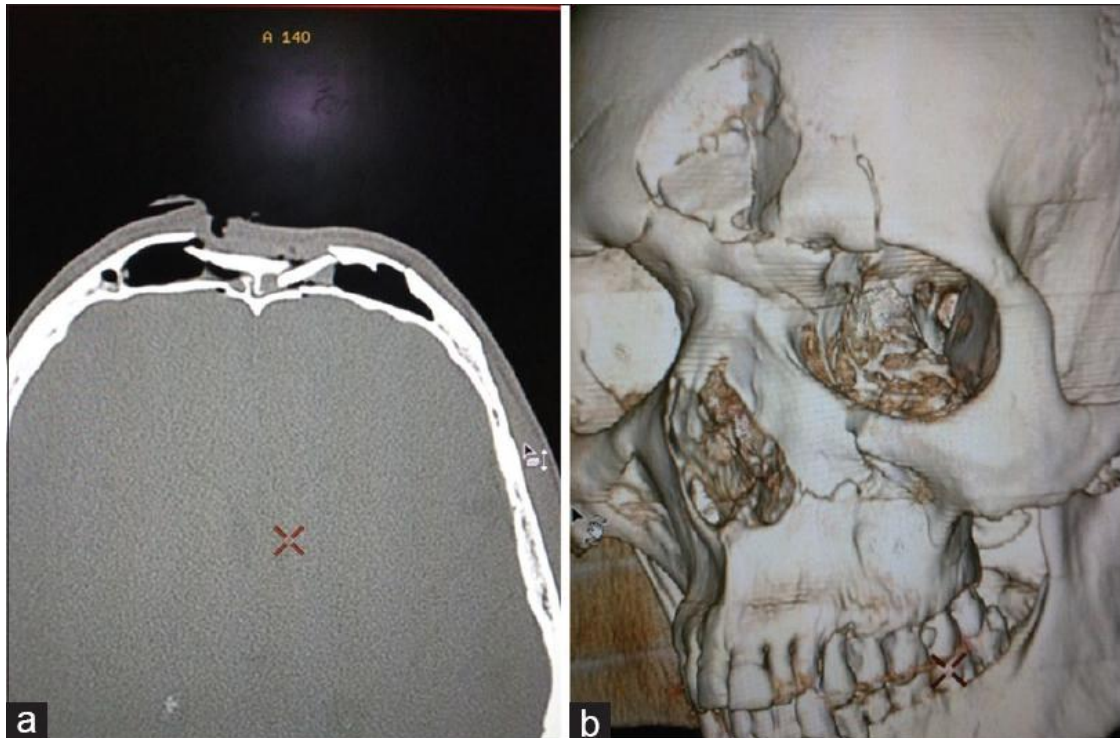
(a) Comminuted depressed fracture of the frontal bones on axial CT. (b) 3 D rendered images showing better description of displacement of the frontal bone fracture; however, the posterior extent could not be appreciated.
